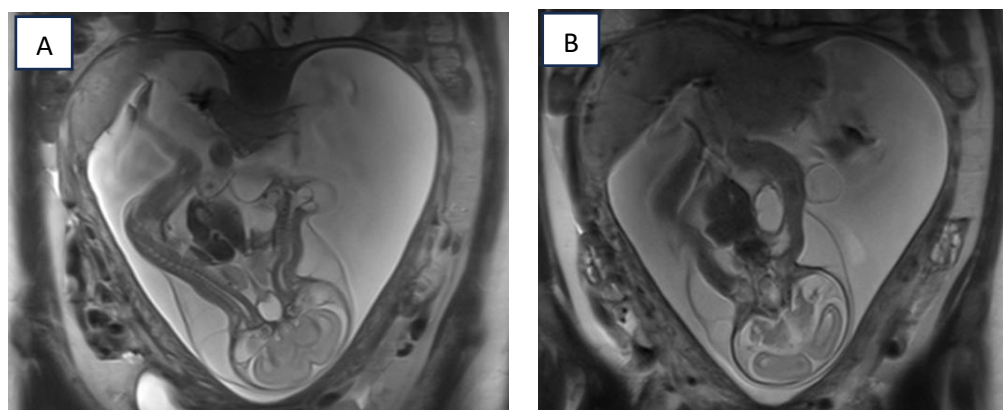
MRI results show two cerebellum lobes, two spines, two hearts, two lungs, and two livers. This organ fused on head to abdomen. Hydronephrosis and meningocele are also seen in this small fetus.
